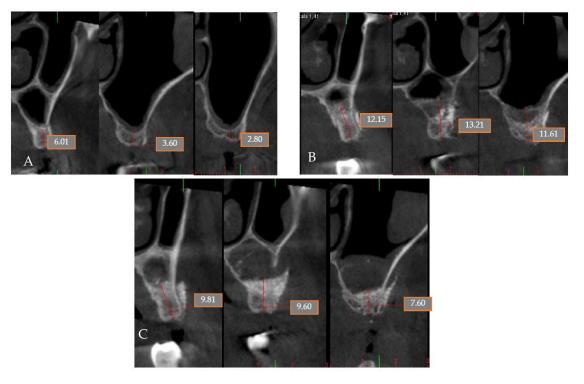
(A) Preoperative CBCT at level 24, 25, and 26; (B) Immediate postoperative CBCT at level 24, 25, and 26; (C) Postoperative CBCT after 4 months at level 24, 25, and 26.
